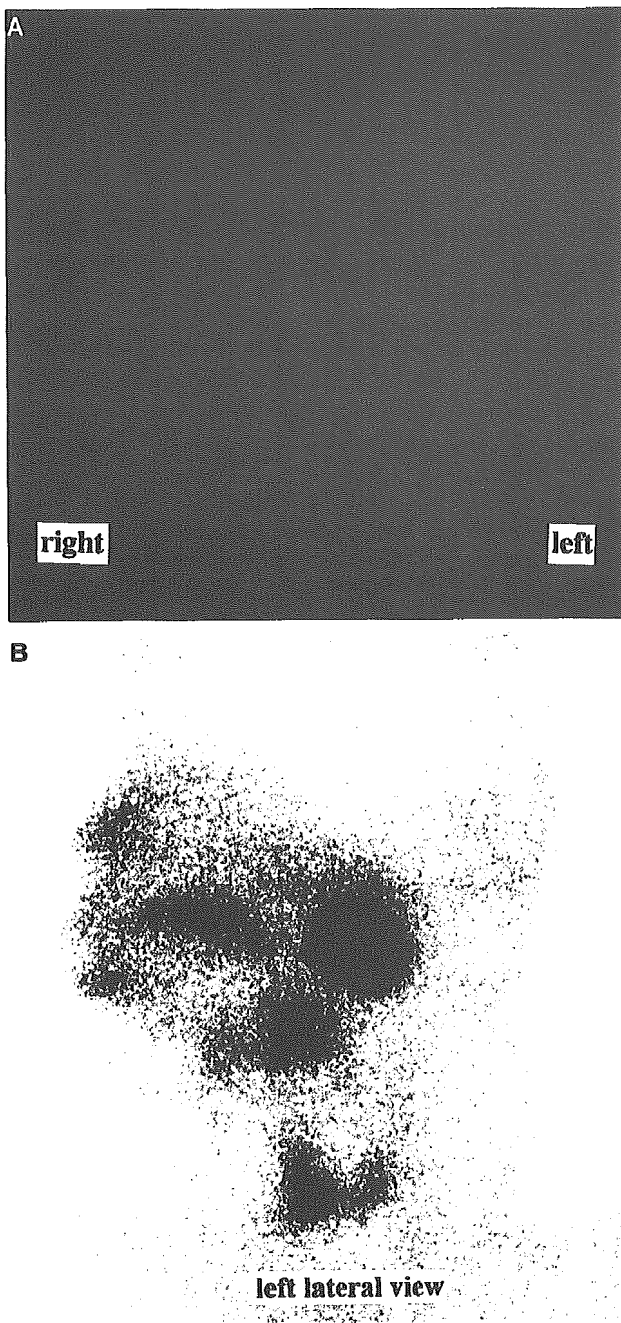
A 46-year-old woman with Warthin's tumor. (A) Increased FDG uptake in the tumor is seen, whereas (B) Tc-99m salivary gland scintigraphy (postoral citric acid stimulation) shows increased radioactivity. In this case, we could rule out malignancy by performing Tc-99m salivary gland scintigraphy first and avoid the false-positive result by FDG PET.
